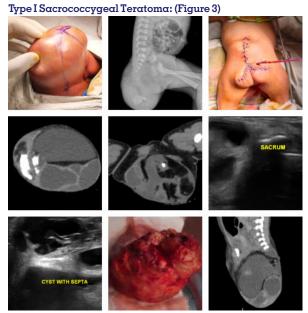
Shows clinical, Radiographic, CT and USG pictures of the 2 day old female who presented with sacrococcygeal mass.
